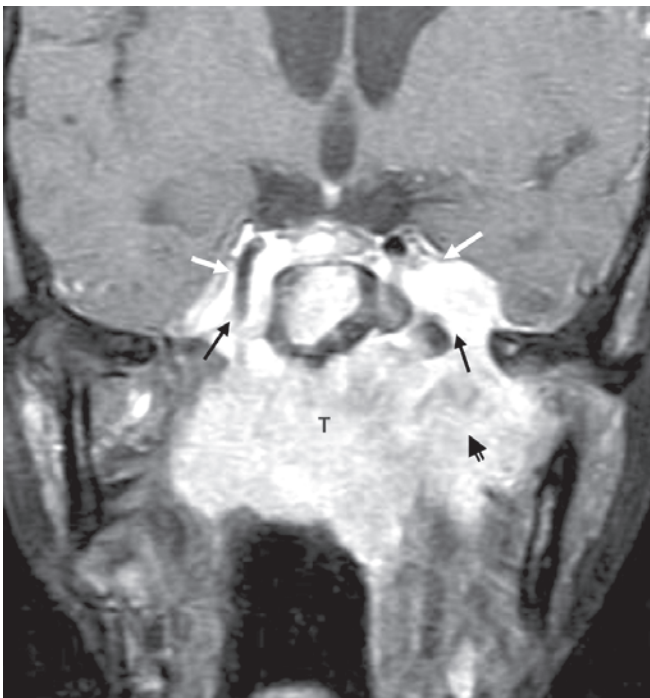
Carcinoma of the nasopharynx. Coronal T1 weighted, fat suppressed, contrast enhanced MR image shows an enhancing lesion (T) in the nasopharynx with extension into bilateral cavernous sinuses (white arrows) via foramen ovale (black arrows). Both cavernous internal carotid arteries are encased by the lesion. There is also extension into left infratemporal fossa (small open black arrow)
